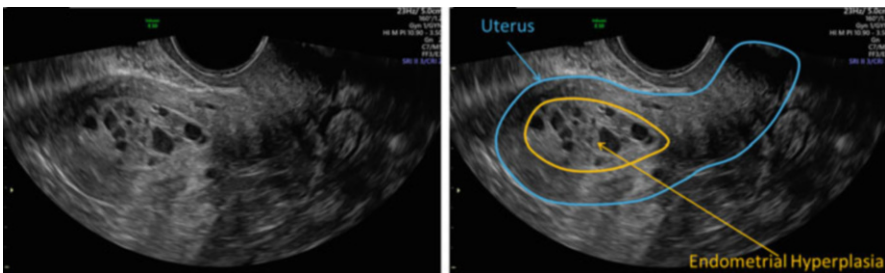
Ultrasound of endometrial hyperplasia. A “swiss cheese” appearance is commonly seen with endometrial hyperplasia, though a tissue diagnosis is required to confirm the diagnosis. The diagnosis of endometrial hyperplasia is also suggested when the endometrial echo is thickened (≥ 4 mm) in the postmenopausal patient
